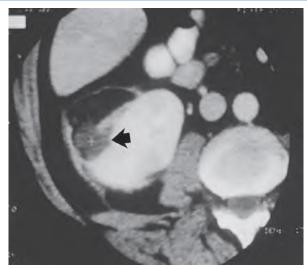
Intrarenal abscess. This computed tomography scan shows an intrarenal abscess, evident as a well-delineated hypodense lesion (arrow), extending into the intrarenal space. (Courtesy Dr. M. Bergeron.)
